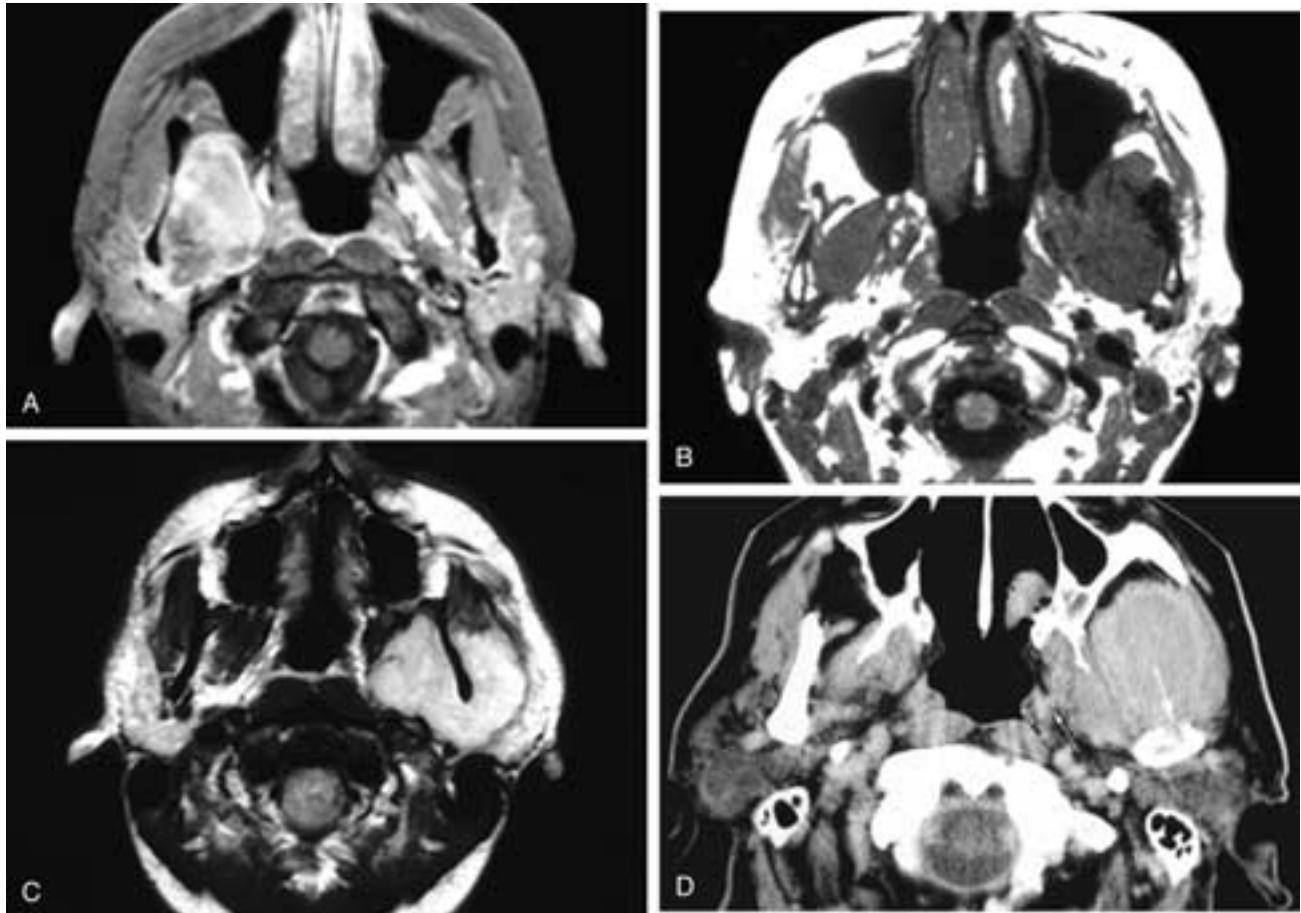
Axial T1-weighted MR image (A) shows an enhancing mass in the right masticator space. This periosteal osteosarcoma causes the medial masticator space fascia to bulge medially, but there is no invasion of the parapharyngeal space. Axial T1-weighted MR image (B) shows a left masticator space mass that has invaded the pterygoid muscles and is limited to the medial portion of the masticator space. This undifferentiated sarcoma is contained by the medial masticator fascia, and there is no extension into the parapharyngeal space. Axial T2-weighted MR image (C) shows a left masticator space sarcoma with high signal intensity that has invaded the masticator muscles but remains contained by the masticator space fascia. Axial contrast-enhanced CT scan (D) shows a destructive left masticator space mass that has eroded the anterior left mandibular head (*large arrow*). Despite its aggressive nature, the masticator fascia prevents this sarcoma from spreading outside the masticator space except in the most anterior medial margin of this space (*small arrow*).
